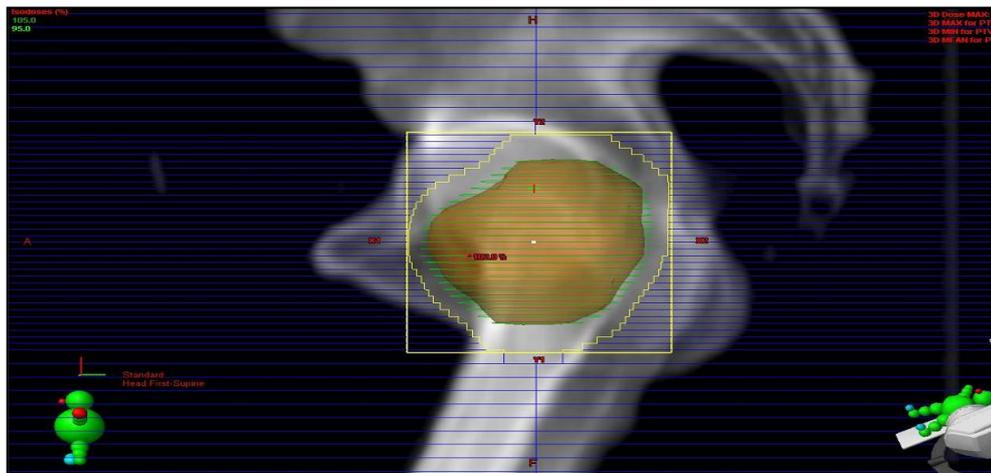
Multi-leaf Collimator (MLC) in TPS (Prostate sagittal CT image).
